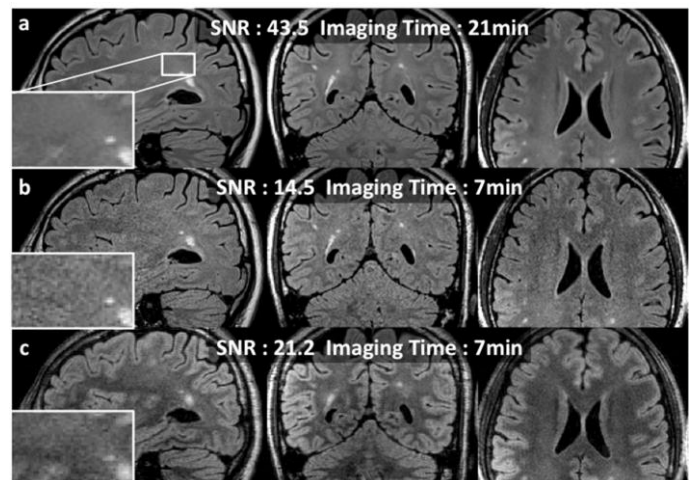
Whole brain isotropic images with SNR and imaging time: the conventional FLAIR (a), the conventional FLAIR with GRAPPA (b) and the proposed Combo-FLAIR (c).
